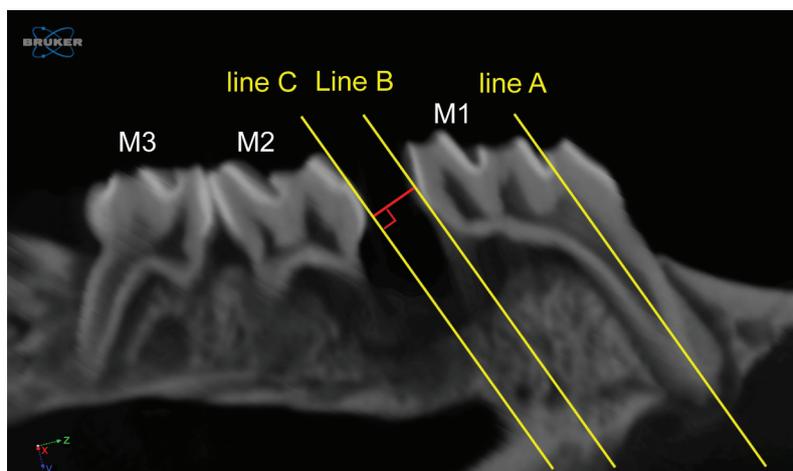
Sagittal cross-sectional view of X-ray μ -computed tomography images. A reference plane was established to include the sagittal plane passing through the mesial root apex of the maxillary right first molar (M1), distal root apex of the third molar (M3), and proximal maximal convexity of the M1 crown. The central axis of the mesial root of M1 on the reference plane is defined as line A. Line B represents a line parallel to line A, tangent to the distal maximal convexity of the M1 crown. Line C represents a line tangent to the proximal maximal convexity of the maxillary right second molar (M2) crown. The perpendicular distance between lines B and C was considered as tooth displacement.
